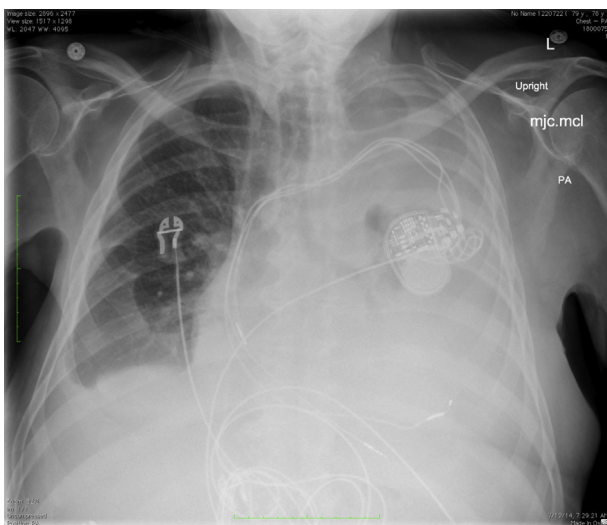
Chest radiograph taken during the week before death. Note opacification in left pleural cavity which limits visualization of the heart contours and the trapped lung.
